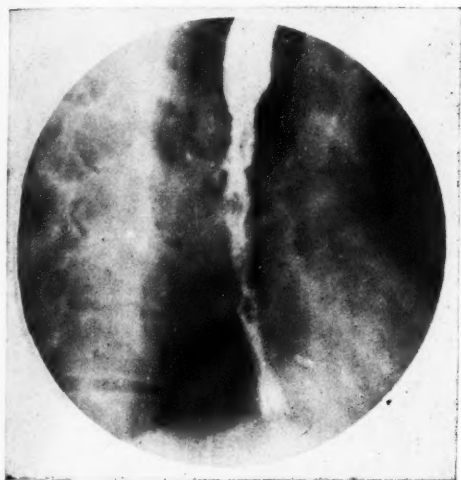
(A386310). Carcinoma of the esophagus with typical radiographic findings.
